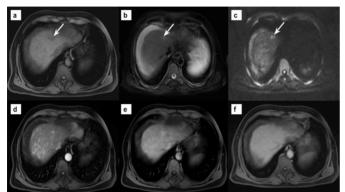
MR images showing two adjacent nodular lesions of 5 mm and 6 mm in segment IV of the liver (arrows). The lesions are hypointense on T1-(a) and hyperintense on T2-weighted images (b) and demonstrate diffusion restriction (c). Note the arterioportal shunts on the arterial phase T1-weighted image (d) that obscure the lesions' arterial enhancement. On the late phase contrast-enhanced T1-weighted image (e), no washout is visible, and the lesions are almost isointense with the liver parenchyma on hepatocyte-specific phase image (f).
